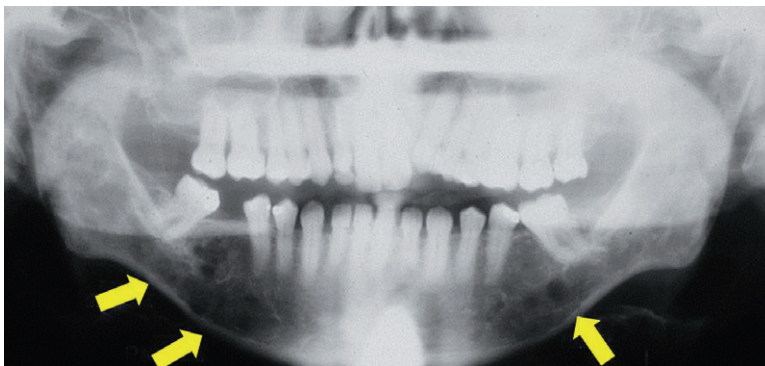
Panoramic radiograph of a 47-year-old African-American male with late-stage IIIB multiple myeloma. Note punched-out radiolucencies of the mandible representing lytic bone lesions of the disease.
